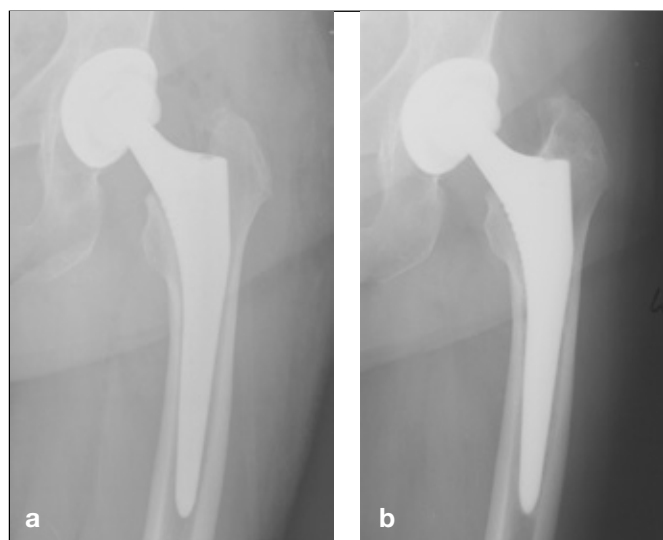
Example radiographs from a 77-year-old female patient taken: (a) postoperatively; and (b) at 5 years; (The subsidence level was 5.5 mm at 2 years).
